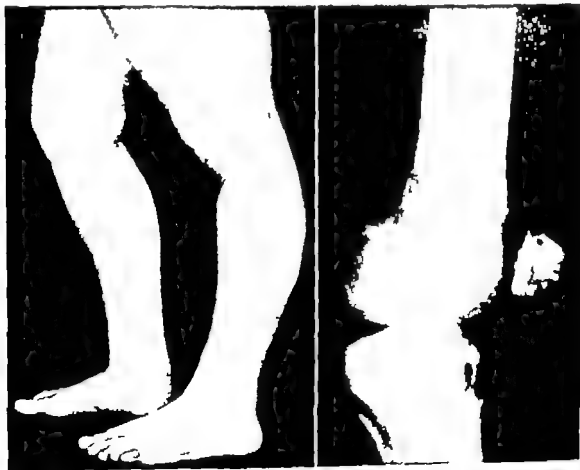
(A) Severe genu recurvatum of left knee following an old fracture of the upper end of the tibia. The patient is a male 18 years old. (B) Roentgenogram taken
